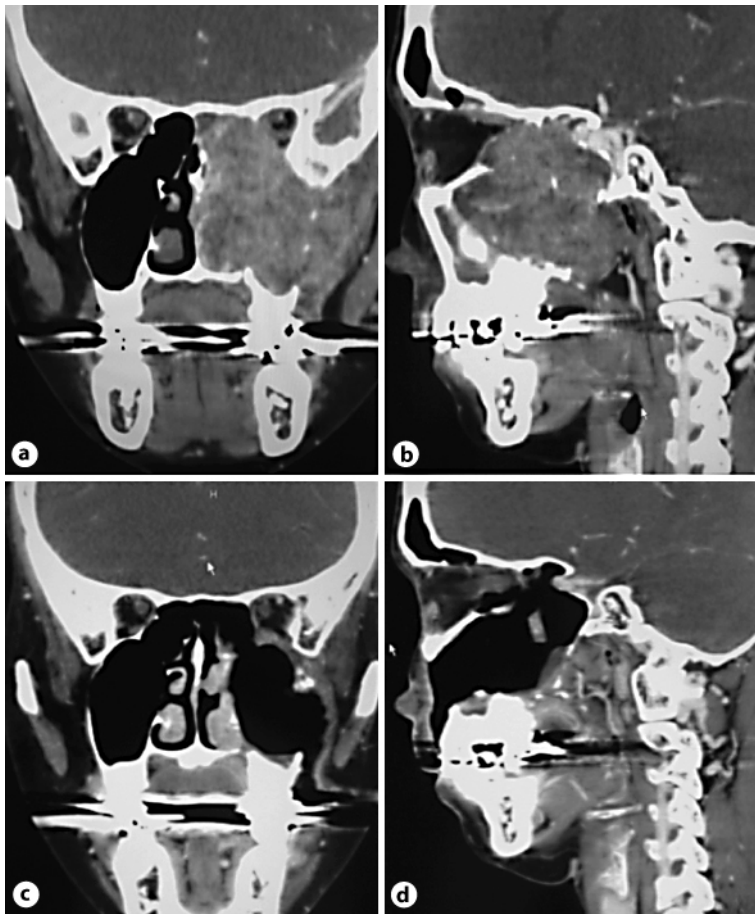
Squamous cell carcinoma of the left maxillary sinus (case No. 1: T4aN0M0). Enhanced CT scan (a coronal view; b sagittal view) shows a tumor in the left maxillary sinus extending to the orbital apex. After treatment, clinical CR was obtained (c coronal view; b sagittal view).
